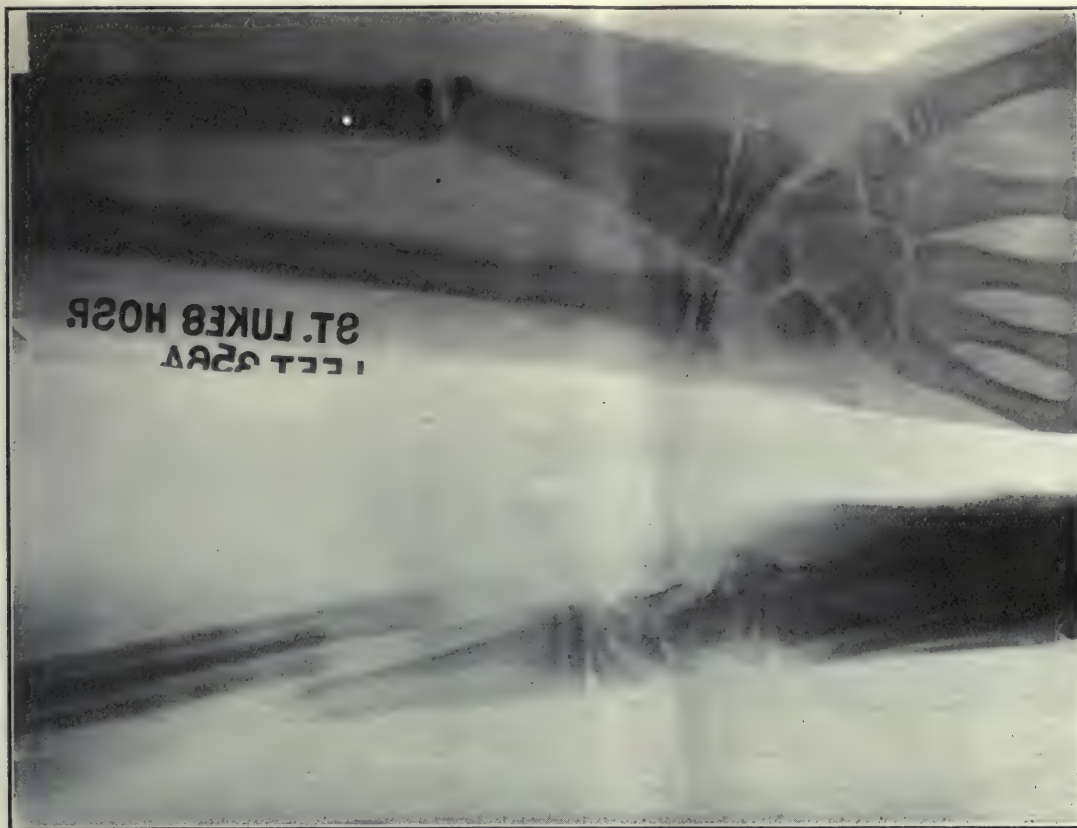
Persistent Overlapping of Radial Fragments Treated by Aluminum Cleat and Steel Screws. The Aluminum Plate is Almost Invisible Owing to Its Transparency to the X-Rays.
